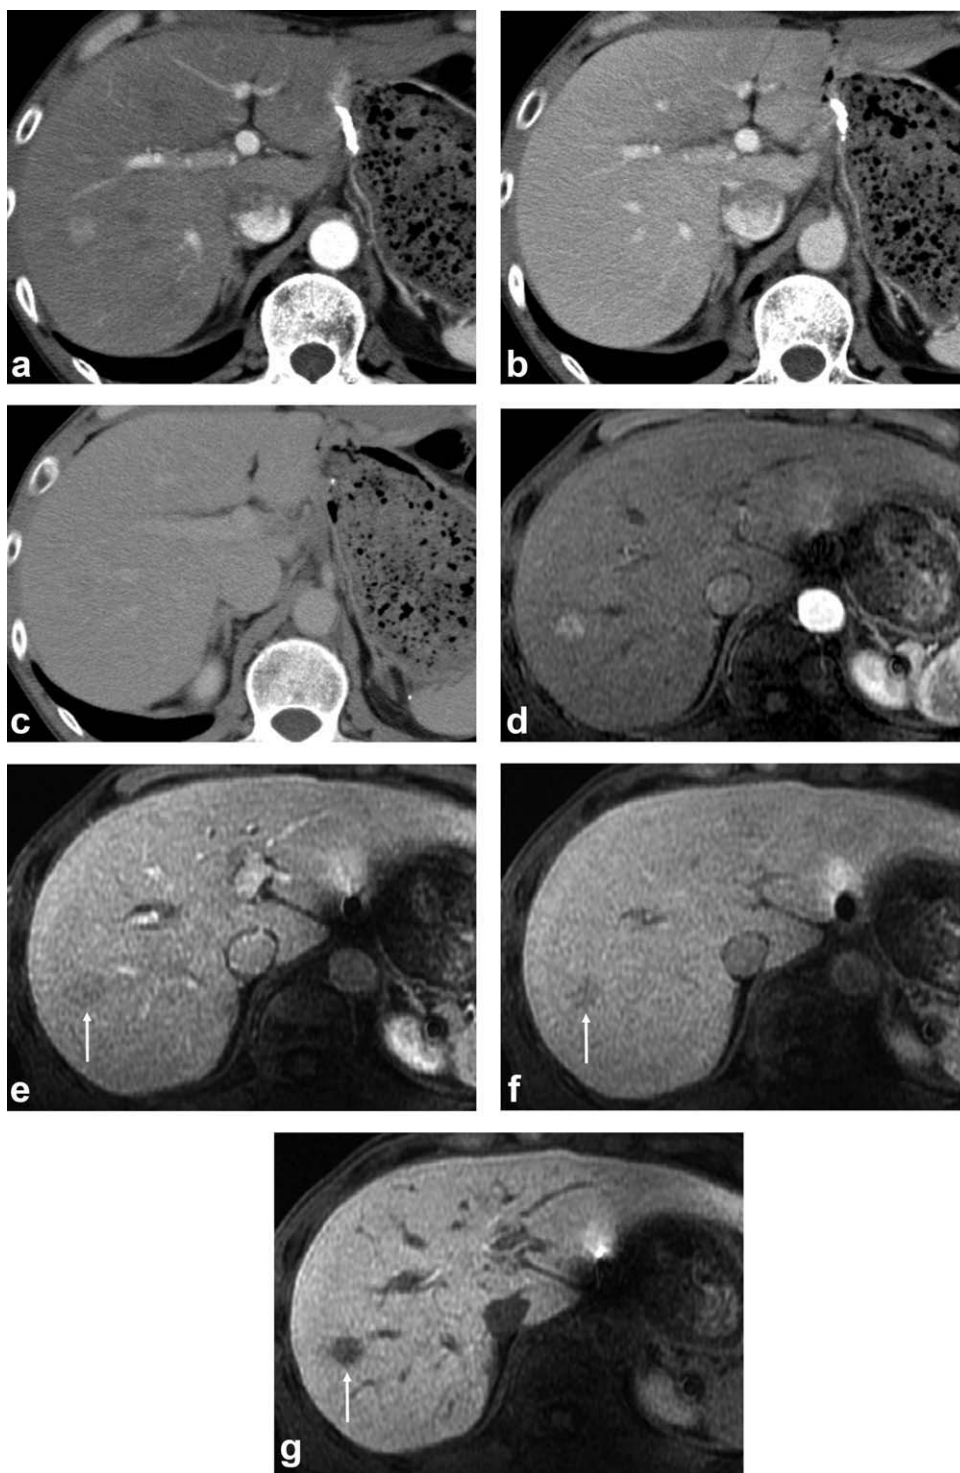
A 55-year-old man with a history of hepatitis C cirrhosis (Child-Pugh A) and biopsy-proven moderately differentiated HCC. (a) MDCT and (d) EOB-enhanced arterial phase MR image demonstrate a hypervascular nodule at segment VI-VII. In (e,f) EOB MR images obtained during portal venous and equilibrium/late phases, rapid washout (arrows) is seen, although this finding is unclear in (b,c) MDCT images obtained during portal venous and equilibrium phases. In (g) the Gd-EOB-enhanced hepatobiliary phase MR image at 20 minutes, the nodule is clearly hypointense (arrow) compared to surrounding liver parenchyma.
